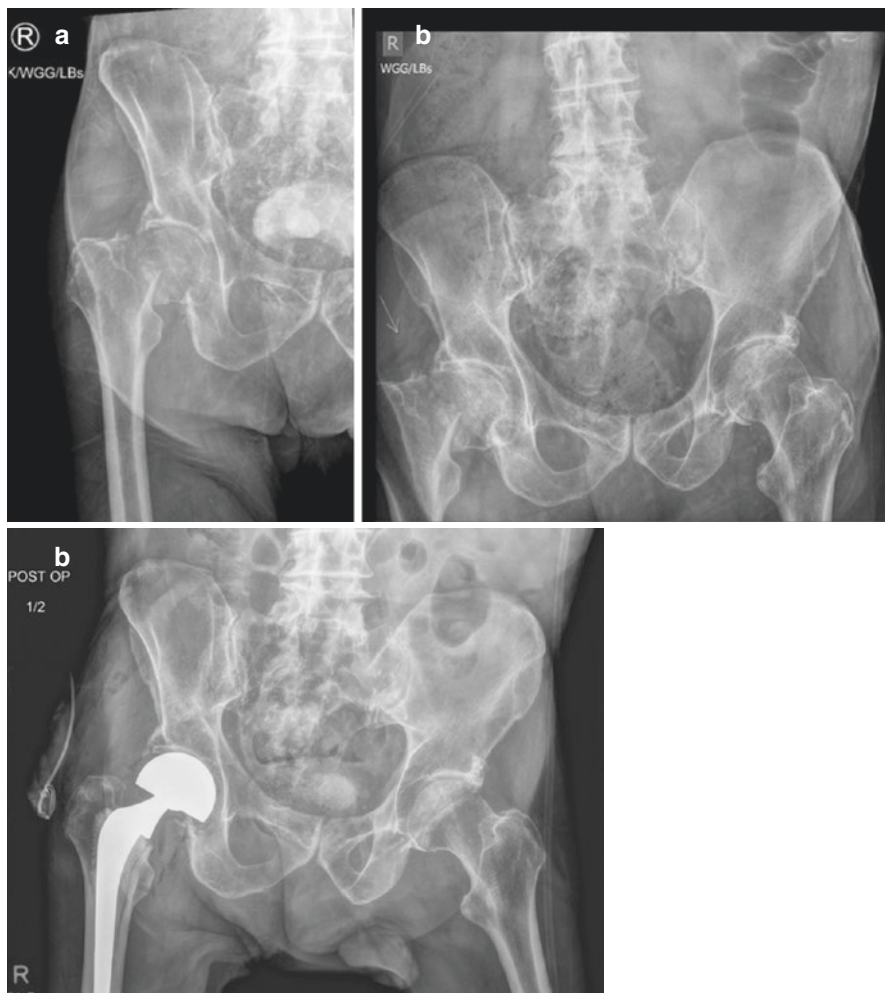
(a) AP of the hip and (b) AP of the pelvis demonstrating a femoral neck pathologic fracture and a (c) postoperative radiograph demonstrating resection and reconstruction with a long stem cemented hemiarthroplasty
